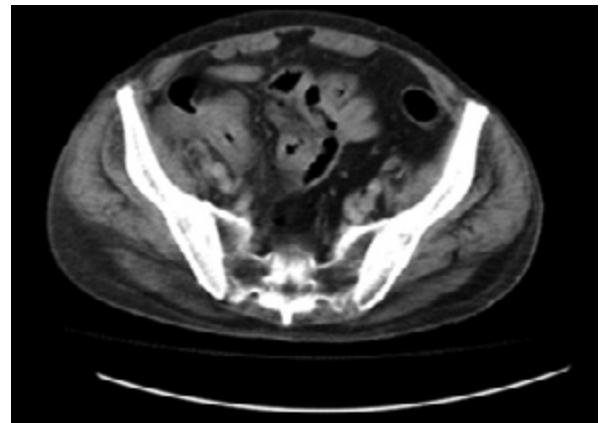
A computed tomography scan shows thickening of the ileal and cecal walls and pericecal fluid and inflammation in the pericecal soft tissue.
